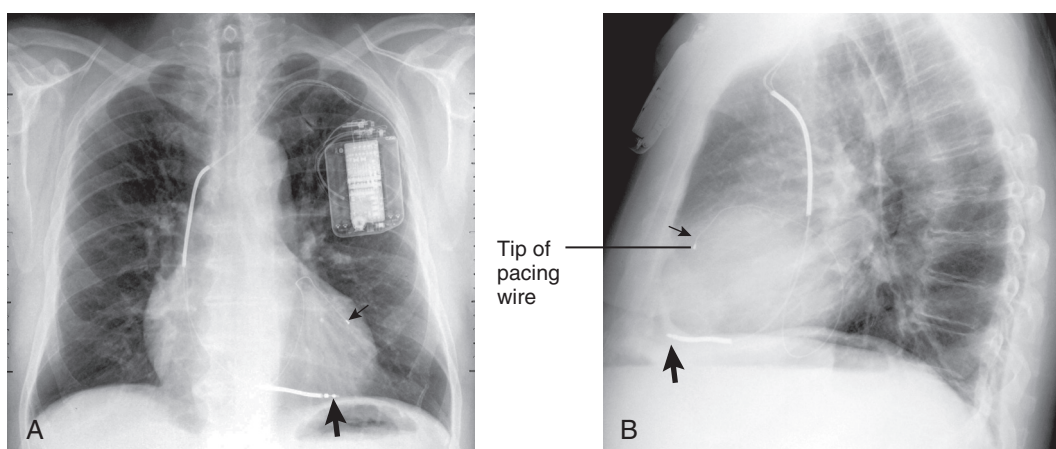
FIGURE e15-12 A, B, Chest radiographs of a 78-year-old man after aortic valve replacement. Note the position of the wire (*small arrow*) through the coronary sinus into the great coronary vein (running parallel to the left anterior descending coronary artery) and biventricular enlargement. Also note the position of the separate ICD tip in the RV apex (*large arrow*).
